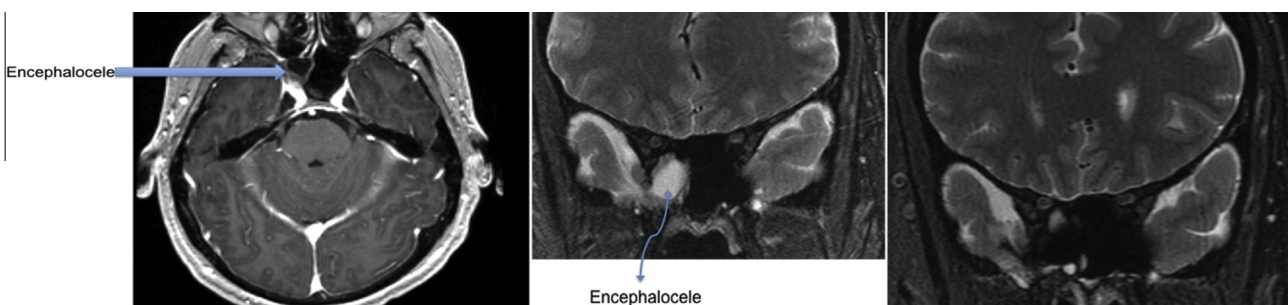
Patient 1. (Left) Axial T1-weighted post-contrast and (center) coronal T2-weighted preoperative MRI showing encephalocele. (Right) Postoperative coronal T2-weighted MRI showing encephalocele repair.
